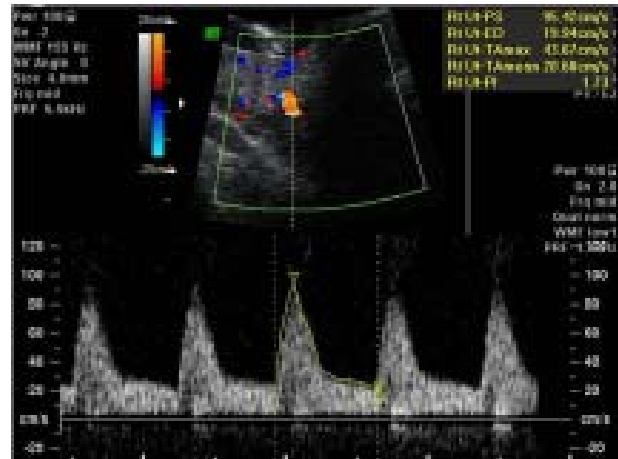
First trimester uterine artery Doppler wave.
